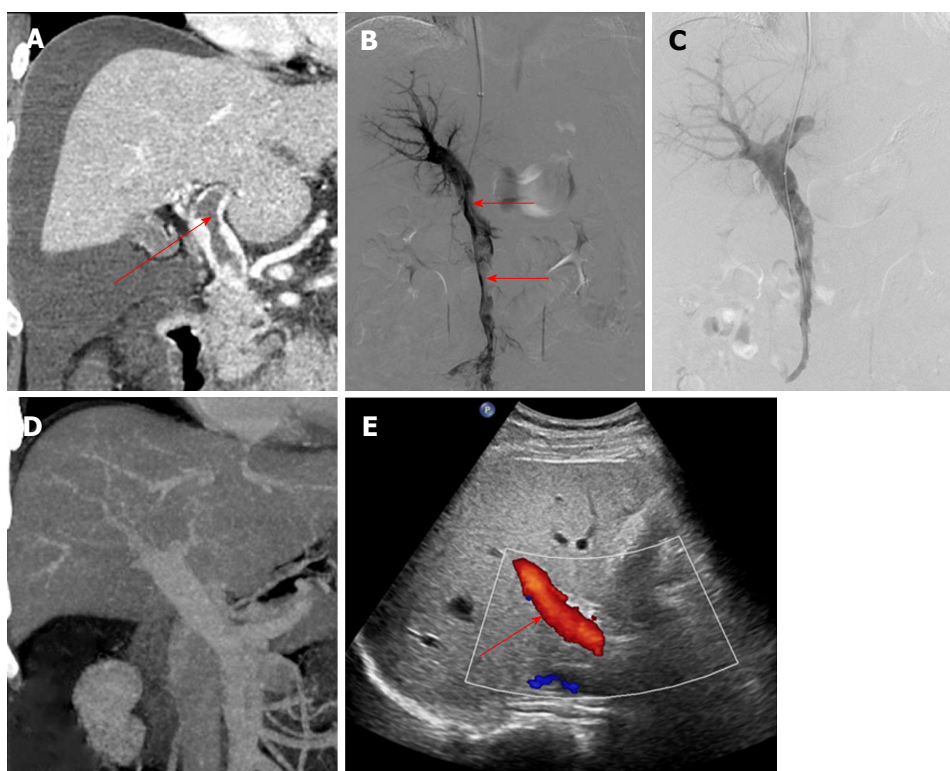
A 29-year-old man had acute abdominal pain and distension for 4 d. A and B: Contrast-enhanced computed tomography (CT) and portography via the transjugular intrahepatic portosystemic route showed thrombus formation in the portal vein and superior mesenteric vein (arrow) with massive ascites; C: Portography after agitation thrombolysis and catheter-directed thrombolysis showed that the filling defect in the portal vein had decreased; D: Contrast-enhanced CT after surgery showed that the thrombus had disappeared completely; E: At 6 mo after treatment, color Doppler ultrasound showed smooth blood flow in the portal vein (arrow).
